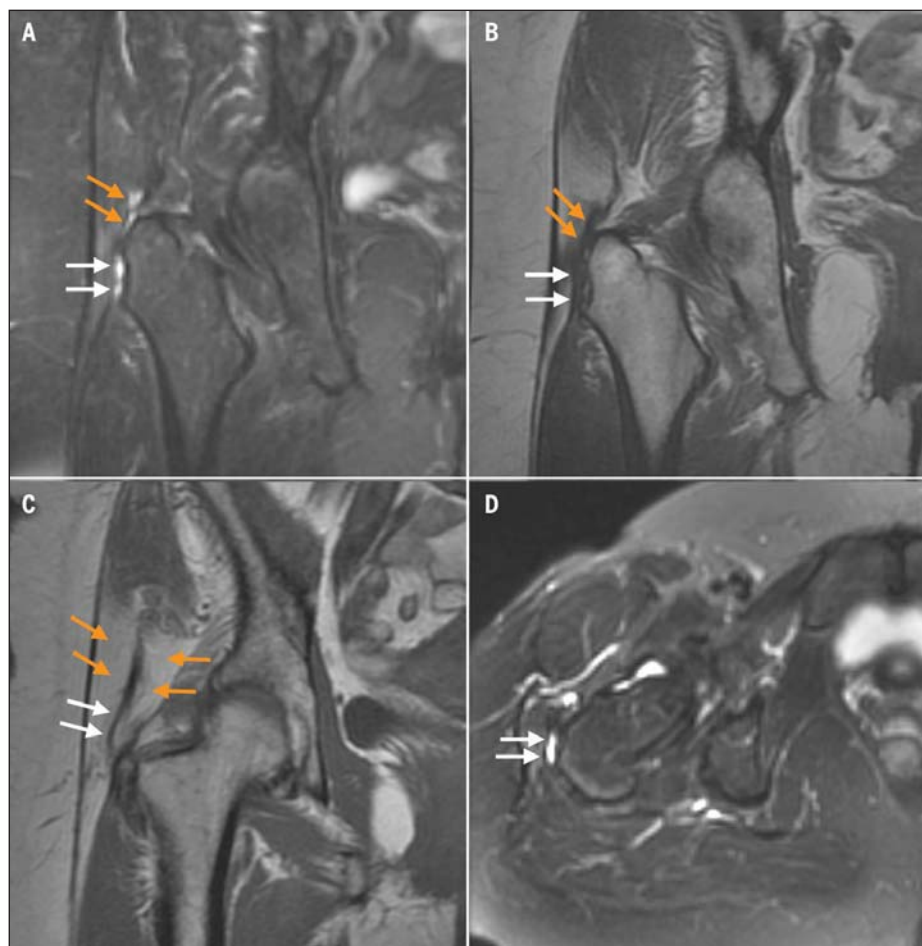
Magnetic resonance images showing gluteal tendon pathology and trochanteric bursitis. (A) On this T2 coronal image, high signal is viewed both superior (orange arrows) and lateral (white arrows) to the greater trochanter, indicating gluteus medius tendon pathology and trochanteric bursitis, respectively. (B) On the corresponding T1 image, these regions of pathology are represented by areas of low signal. (C) Further anteriorly, thinning of the gluteus medius tendon is evident (white arrows) accompanied by muscle atrophy (orange arrows). (D) The area of high signal intensity lateral to the trochanter on this axial T2 fat saturated image (white arrows) corresponds to that viewed in image A.
